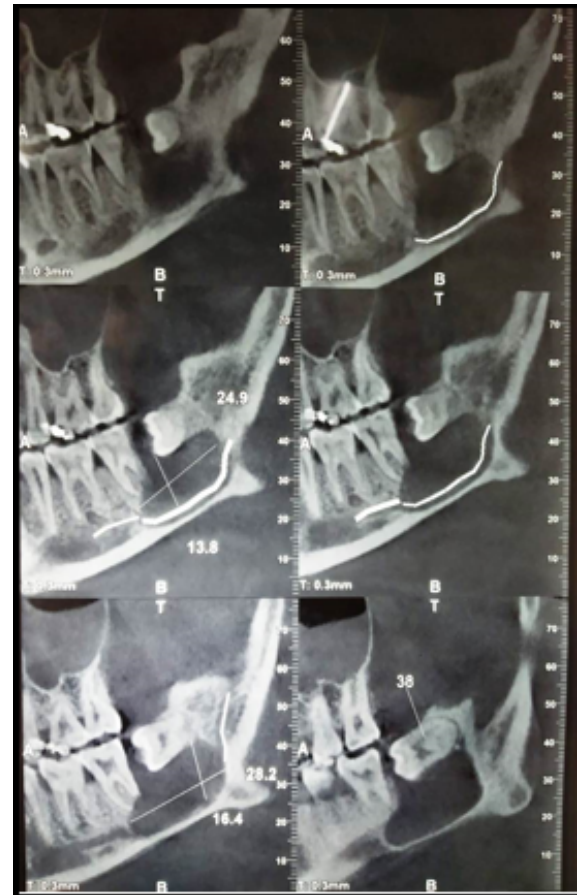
Cone beam computed tomography taken prior surgery
